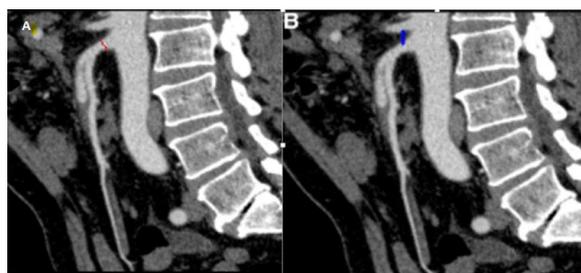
CT parasagittal showing SMA diameter (A) and distance between SMA and Celiac trunk (B).
